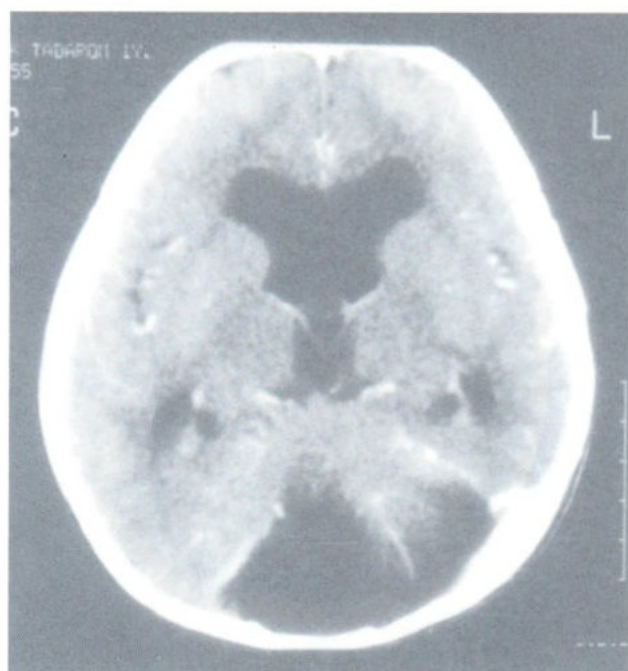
CT brain in axial (A) and reconstructed coronal (B) planes of a boy with frontoethmoidal meningoencephalocele demonstrate absent septum and heterotopia at subependymoid region (A).
